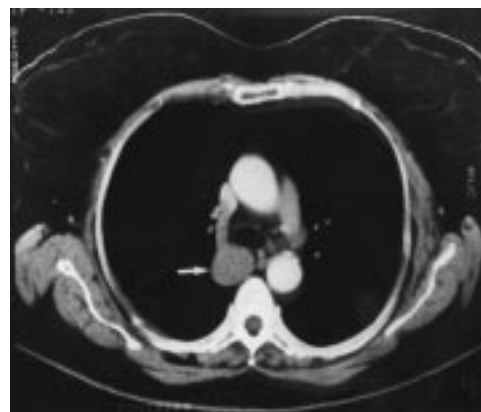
CT section at the level of the azygos arch confirming the presence of a mass located in the azygos path (arrow). No anomalies were seen in higher and lower slices.
